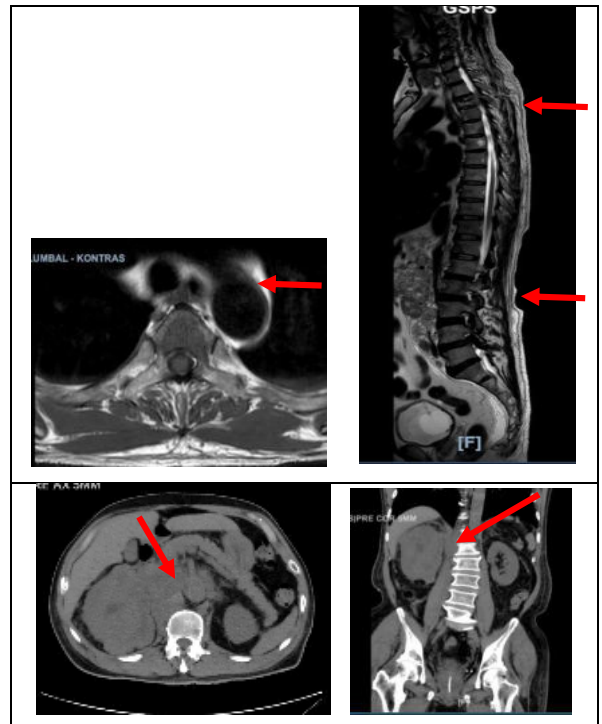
contrast MRI of spine; 1b. Abdominal CT-scan
